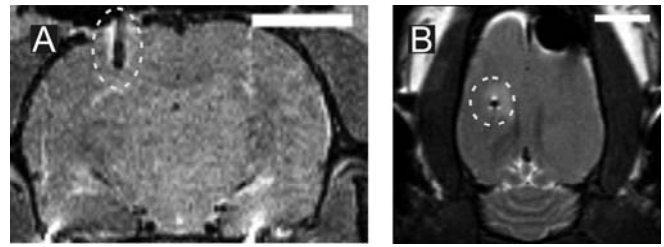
MRI 24hrs after probe implantation. Implanted probe is represented by hypointensive shadows highlighted by hyperintensive edge (dashed ellipses). A – 3D Turbo RARE coronal projection. Probe shadows closely resemble the shape of the fabricated device. B – 3D T2* FLASH axial projection. The hyperintensive region around the implantation site indicates the presence of minimal post-operative brain edema. Scale bars – 5 mm.
